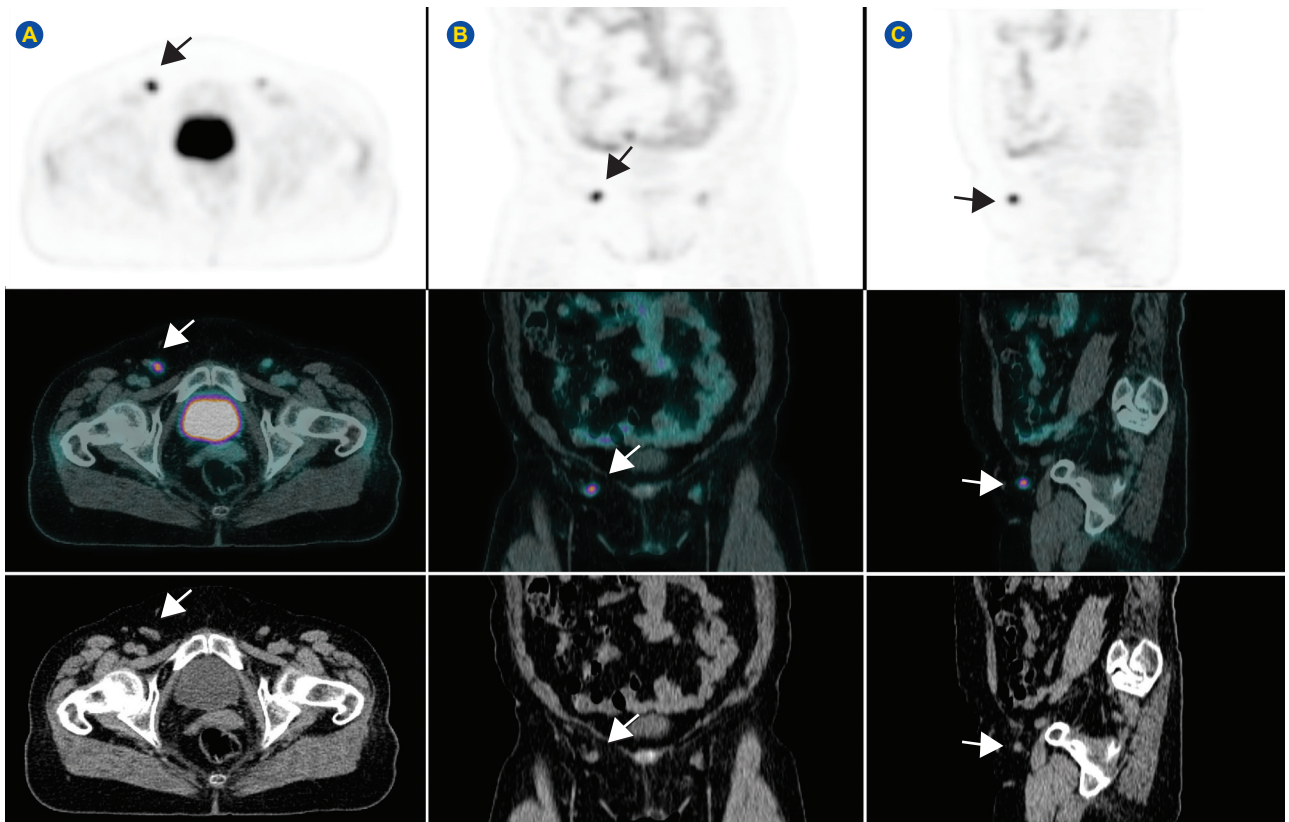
18F-FDG-avid metastatic inguinal lymph node (arrows on PET, PET/CT and CT in axial A, coronal B, and sagittal C planes)
